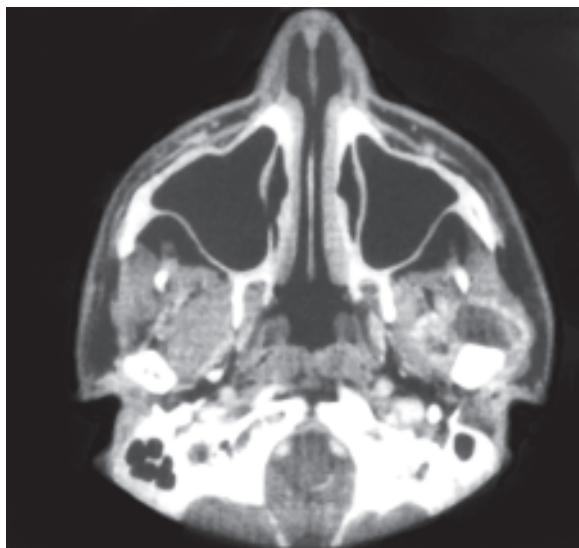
CT scan in the axial plane. Note the gray soft tissue imaging and the radiopaque bone
